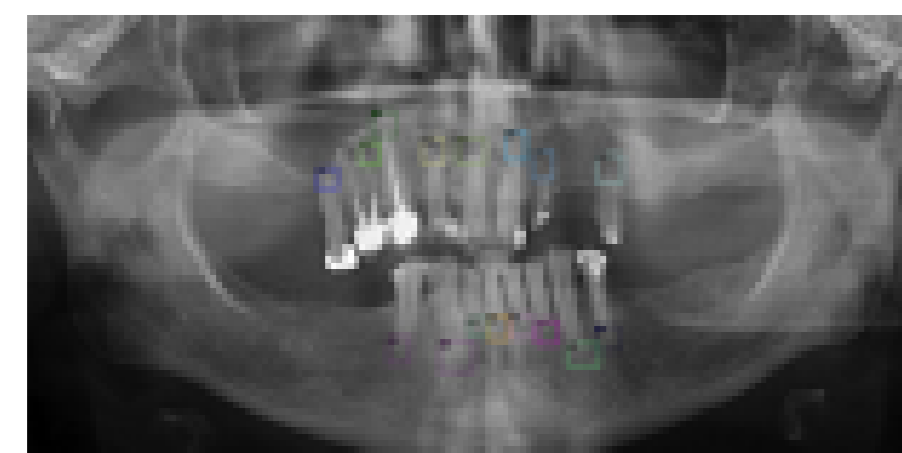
Annotating the periapical lesions
